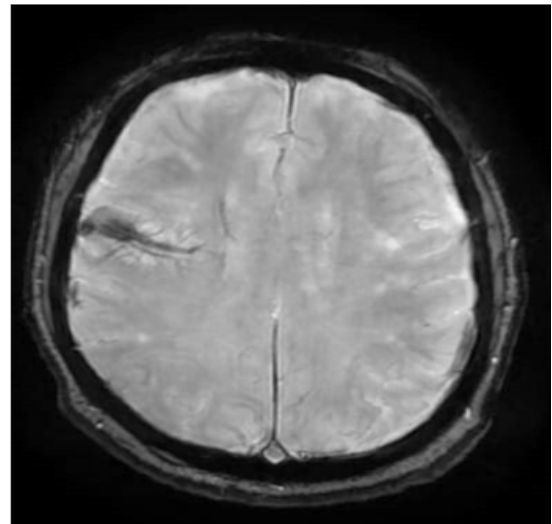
Axial MRI SWAN sequence showing a straight posterior frontal dilated venous tract with “caput-medusae” head branching, extended to the deep white matter level, which spills into a cortical vein draining into the superior sagittal sinus.
